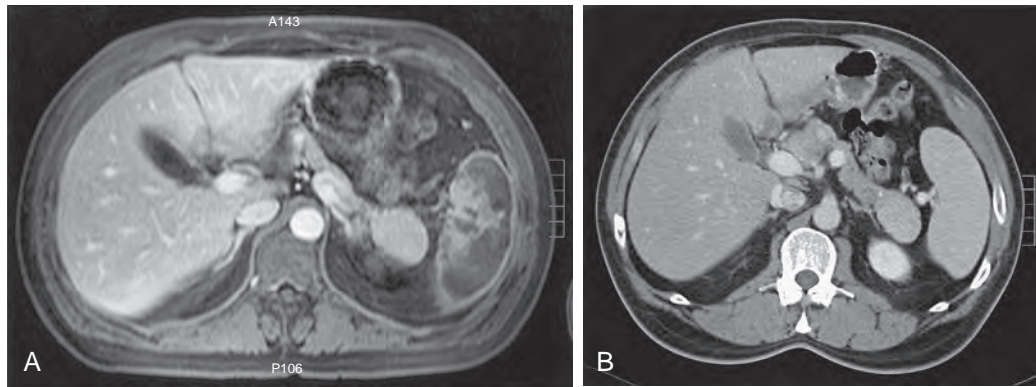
Accessory spleen within the tail of the pancreas mimicking a mass. A. The contrast-enhanced fat suppression T1-weighted MR image that was obtained because of the patient's left upper quadrant pain reveals areas of infarction of the spleen. There is a well-defined homogeneous mass in the tail of the pancreas displaying signal intensity similar to that of the upper part of the spleen (not shown). B. On review of the contrast-enhanced CT scan that was obtained 2 years earlier, the mass has not changed. On a prior study, it was presumed to represent spleen, and a nuclear medicine examination proved the nature of the mass to be accessory spleen in the tail of the pancreas.
